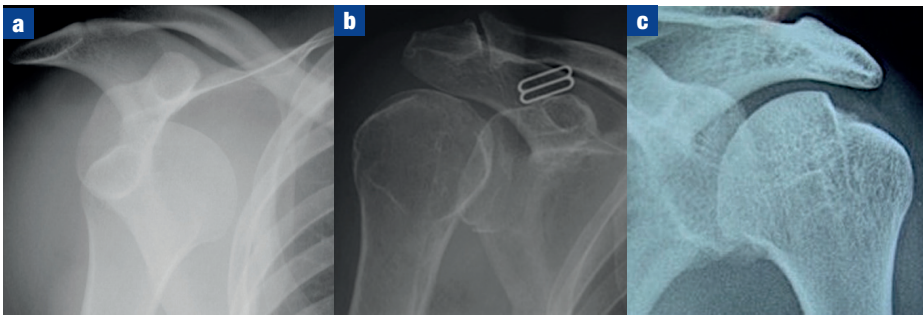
Anteroposterior X-rays of the shoulder. a. An anterior dislocation; the humeral head sits medial and inferior to the glenoid. b. Posterior dislocation; the humeral head is rotated internally, causing a light bulb appearance. c. A Hill-Sachs lesion; a posterolateral indentation occurs on the humeral head at or above the level of the coracoid.
